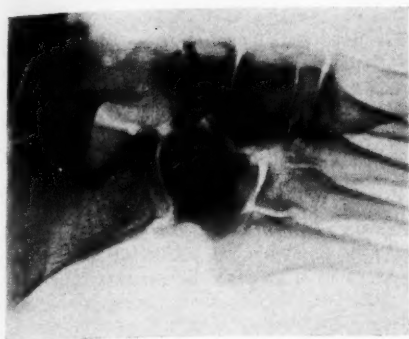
Lateral-oblique roentgenogram of the right foot, showing the localized sclerosing lesion of the cuboid bone and the surrounding normal foot bones and their articulations.
